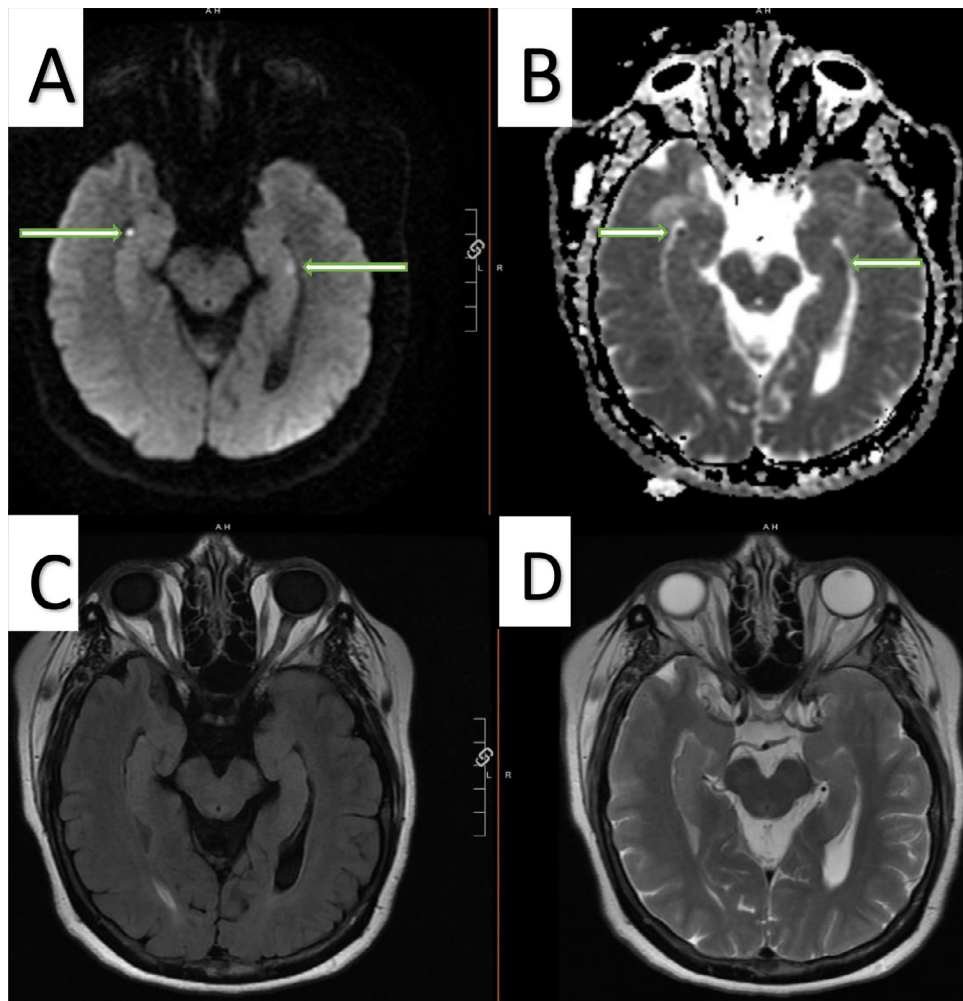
MRI Brain without contrast (A) diffusion weighted images (DWI) showing restricted diffusion in the bilateral medial temporal lobes (arrows) along with corresponding (B) apparent diffusion coefficient (ADC) images- (arrows), (C) fluid attenuated inversion recovery (FLAIR) and (D) T2 sequence.
